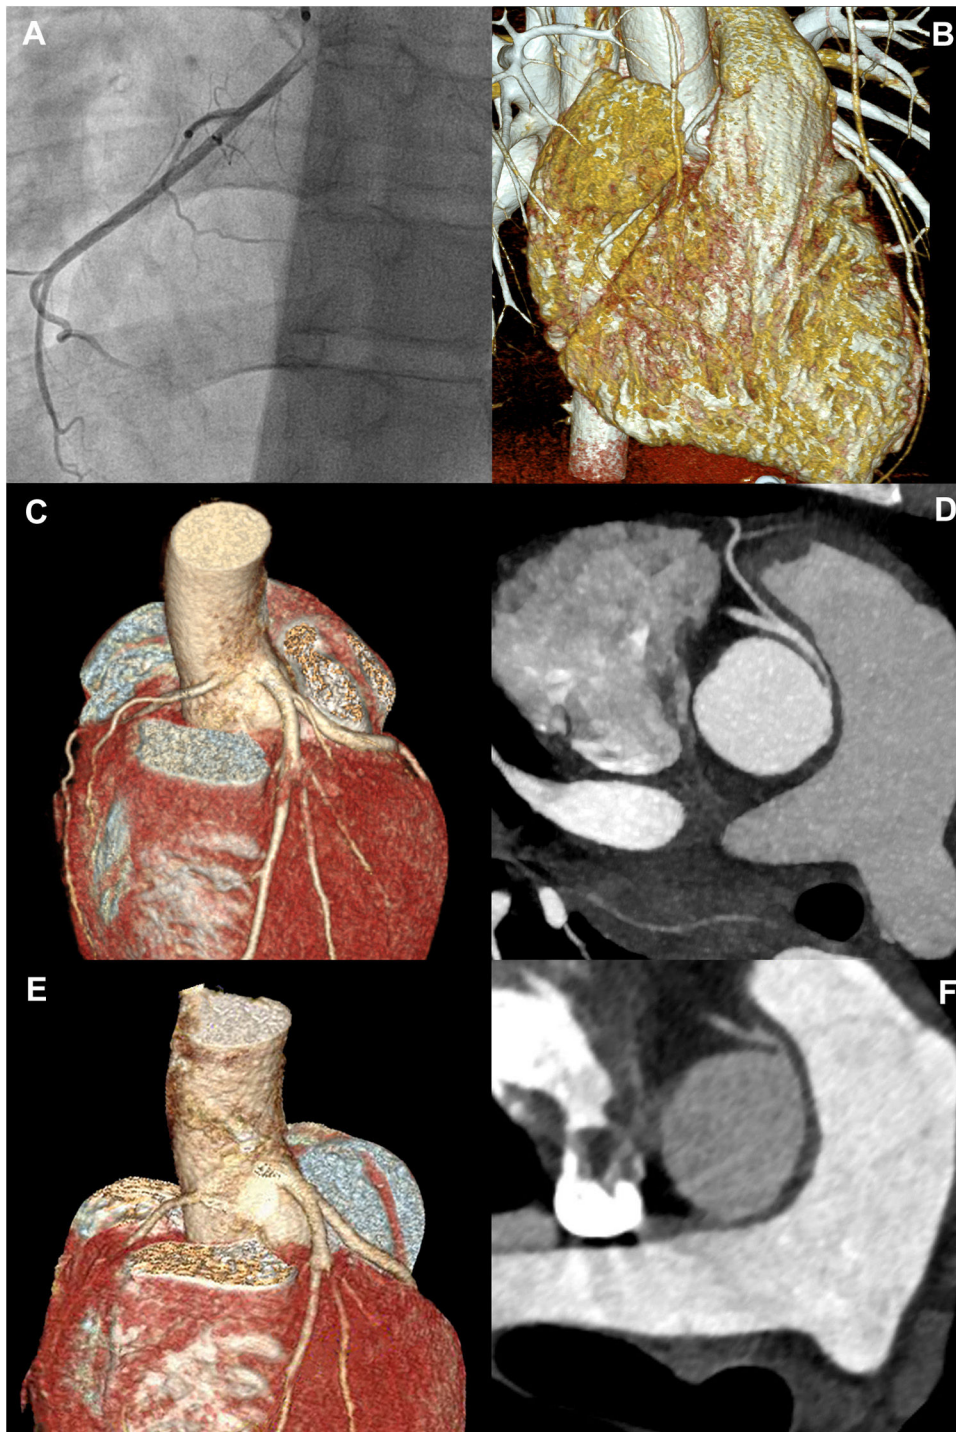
Coronary imaging, including preoperative invasive coronary angiography of the right coronary artery (A); computed tomography coronary angiography volume rendering (B and C) and multiplanar reformatting (D) and postoperative computed tomography coronary angiography volume rendering (E) and multiplanar reformatting (F). Coronary imaging revealed an anomalous origin of the non-dominant right coronary artery from the left sinus of Valsalva, with a slit-like orifice, acute takeoff and an interarterial and intramural course. Postoperative imaging confirmed corrected origin of the right coronary artery without residual stenosis.
